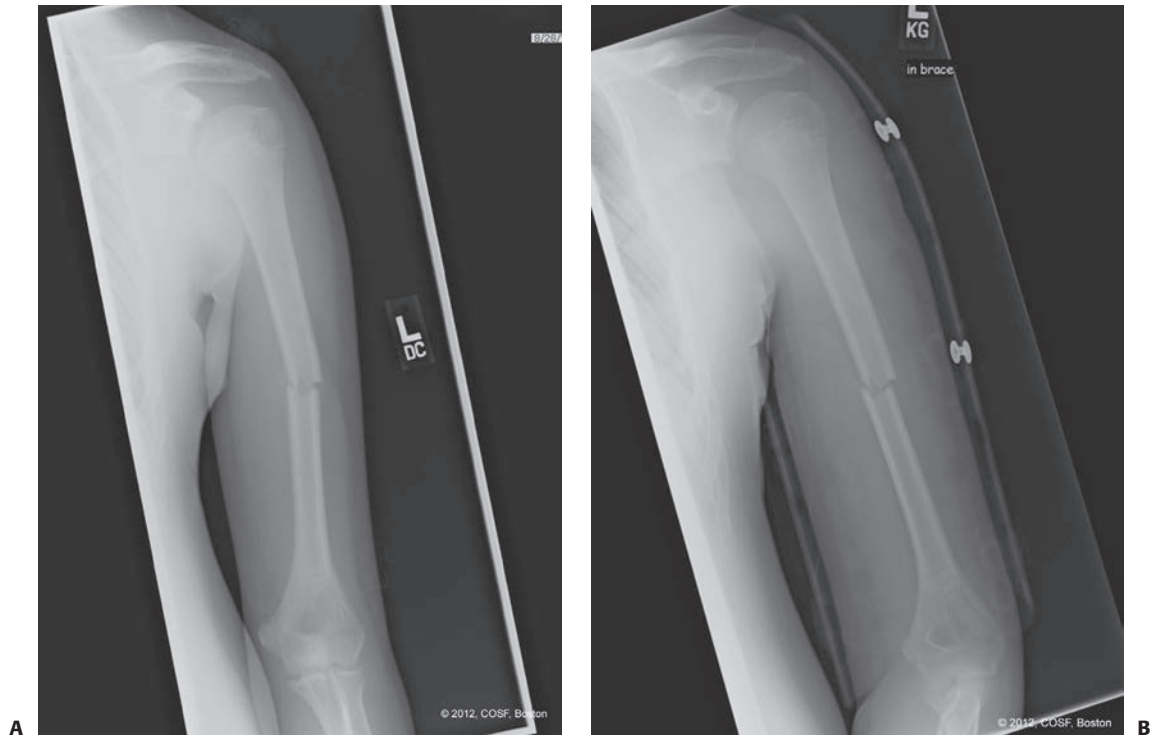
A: AP radiograph of a minimally displaced humeral diaphyseal fracture in a 13-year-old male. B: Radiograph in fracture brace, demonstrating maintenance of alignment.
